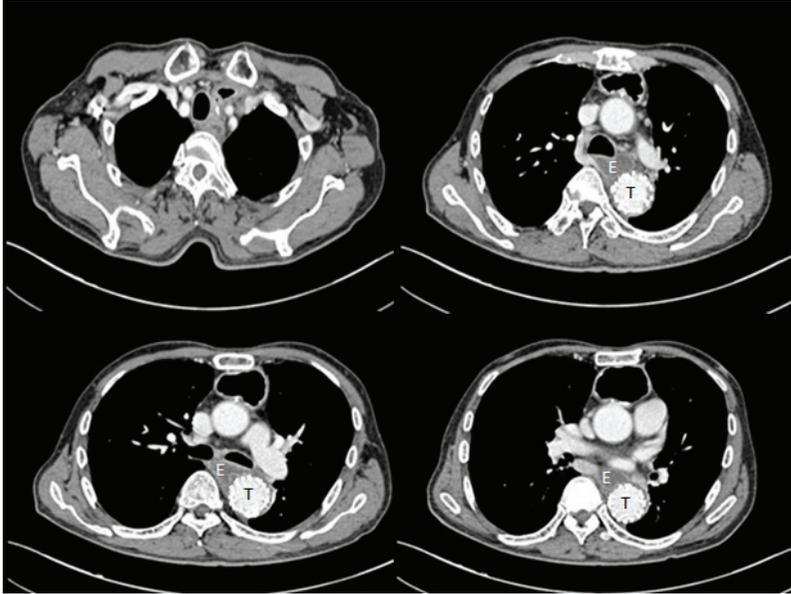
CT scans of a thoracic aortic aneurysm after esophageal bypass surgery showing that the periesophageal air bubble has disappeared. E: esophagus, T: thoracic aorta.
